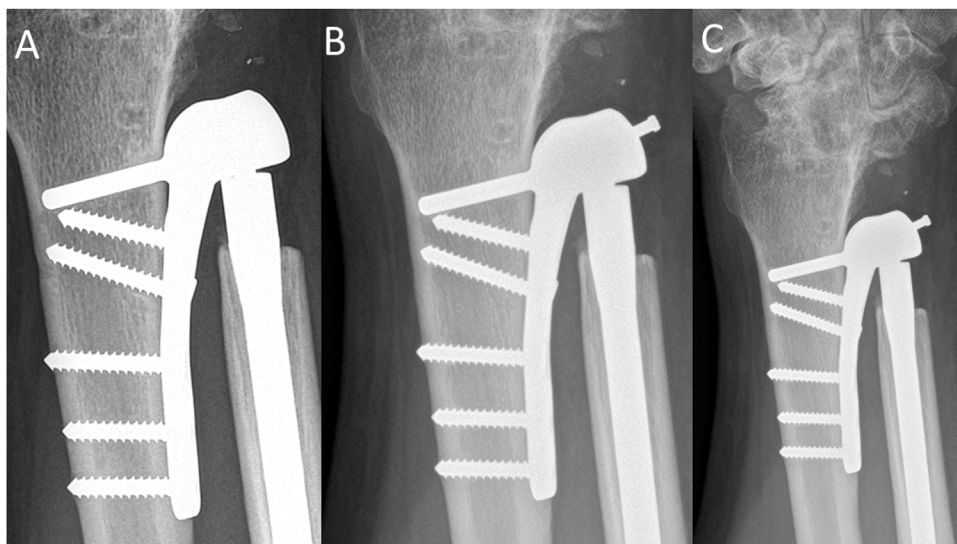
Postoperative X-ray in patient 4 (A). Asymptomatic loosening of the radial cover locking screw seen on X-ray at 3 years (B). A follow-up X-ray taken four months after X-ray B showed no progression in the loosening of the radial cover (C).
